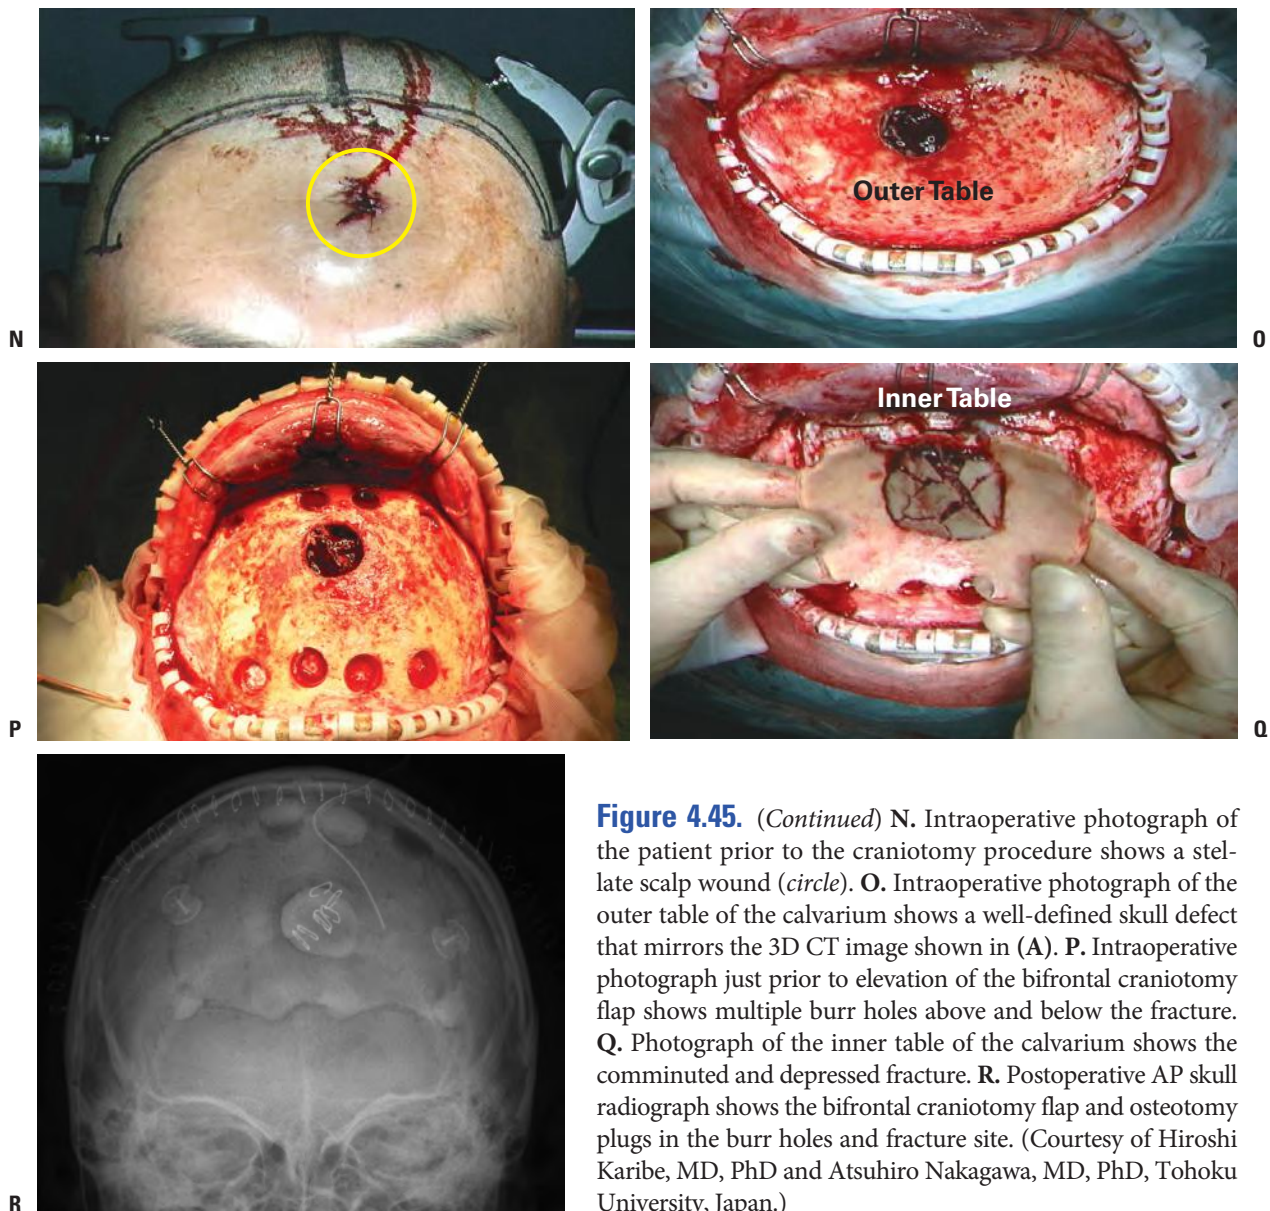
Nonballistic Penetrating TBI (Hammer to Head). A 57-year-old male assaulted with a hammer presented to the ED with a GCS = 15. A. Admission 3D CT performed 3 hours after the injury demonstrates a focal, well-defined, round defect in the midfrontal calvarium (*arrow*). The size and shape of the fracture corresponds exactly to the size and shape of the hammer. B. Admission parasagittal CT reformatted image shows a comminuted depressed fracture with preferential involvement of the inner table of the skull. C. Admission axial CT demonstrates the punched-out defect of the outer table of the skull (*arrow*). D. Admission axial CT viewed at brain window shows the depressed fracture (*asterisk*) and a small cortical contusion (*arrow*). E. Axial FLAIR MRI performed 4 hours after the injury reveals an area of T2 hyperintensity extending from the cortex to the frontal horn of the left lateral ventricle (*circle*); note the normal flow void in the superior sagittal sinus (SSS). A small amount of intraventricular hemorrhage is present (*arrow*). F. Preoperative MR venography confirms no evidence of occlusion of the SSS (*arrow*). G,H. Coronal T2 MRI reveals abnormal T2 hyperintensity extending from the SSS to the left frontal horn (*circle*). The flow void within the SSS appears normal. (*Continued*)
